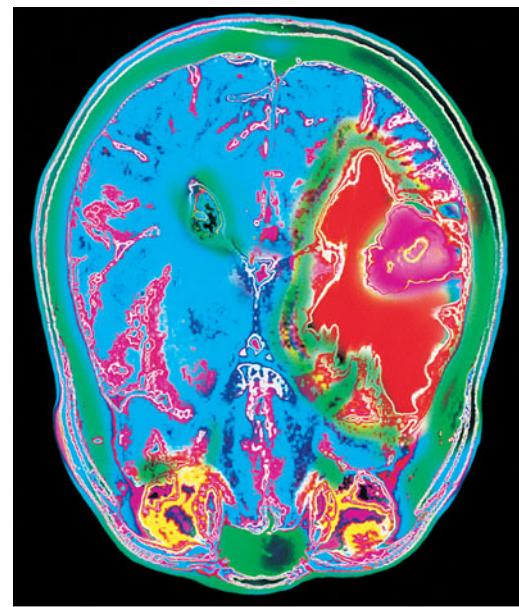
An MRI of the brain. The magenta and red area to the right is a brain tumor.
